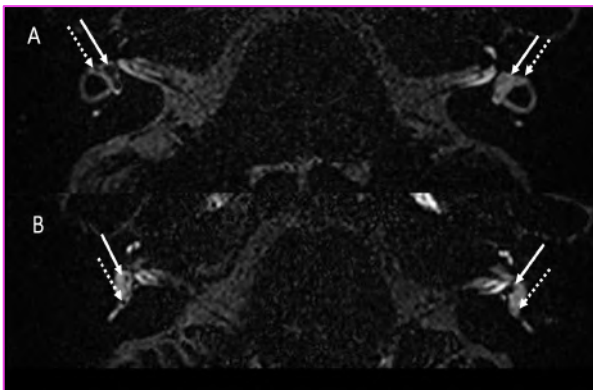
Patient (male, 43 years old) with a left canal and utricular deficit associated with a left vestibular atelectasis on the MRI A/ Axial 3D-FLAIR at the level of the upper part of the vestibule where the entire lateral canal semi-circular canal is displayed. The left utricle (white arrow) and lateral ampulla (white dotted arrow) are collapsed compared to the right side. B/ Axial 3D-FLAIR at the level of the lower part of the vestibule, left and right saccule are normal (white arrow) on left side the posterior ampulla (white dotted arrow) is collapsed compared to the right side
